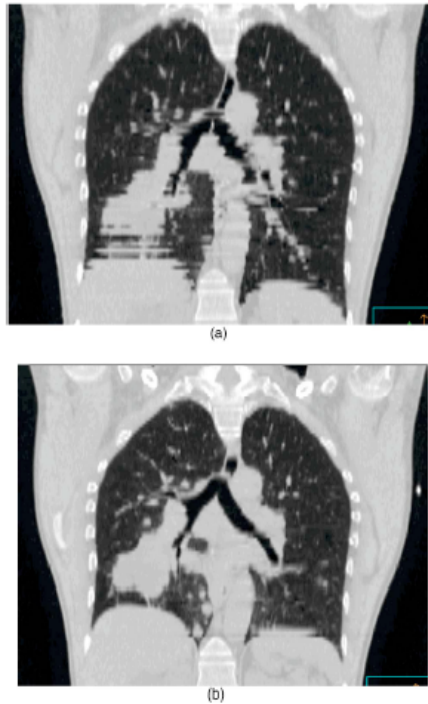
An example of motion artefacts from free breathing during CT. Figure a) shows banding artefacts from the unaccounted motion. Figure b) shows the same patient with respiratory gating [17].
